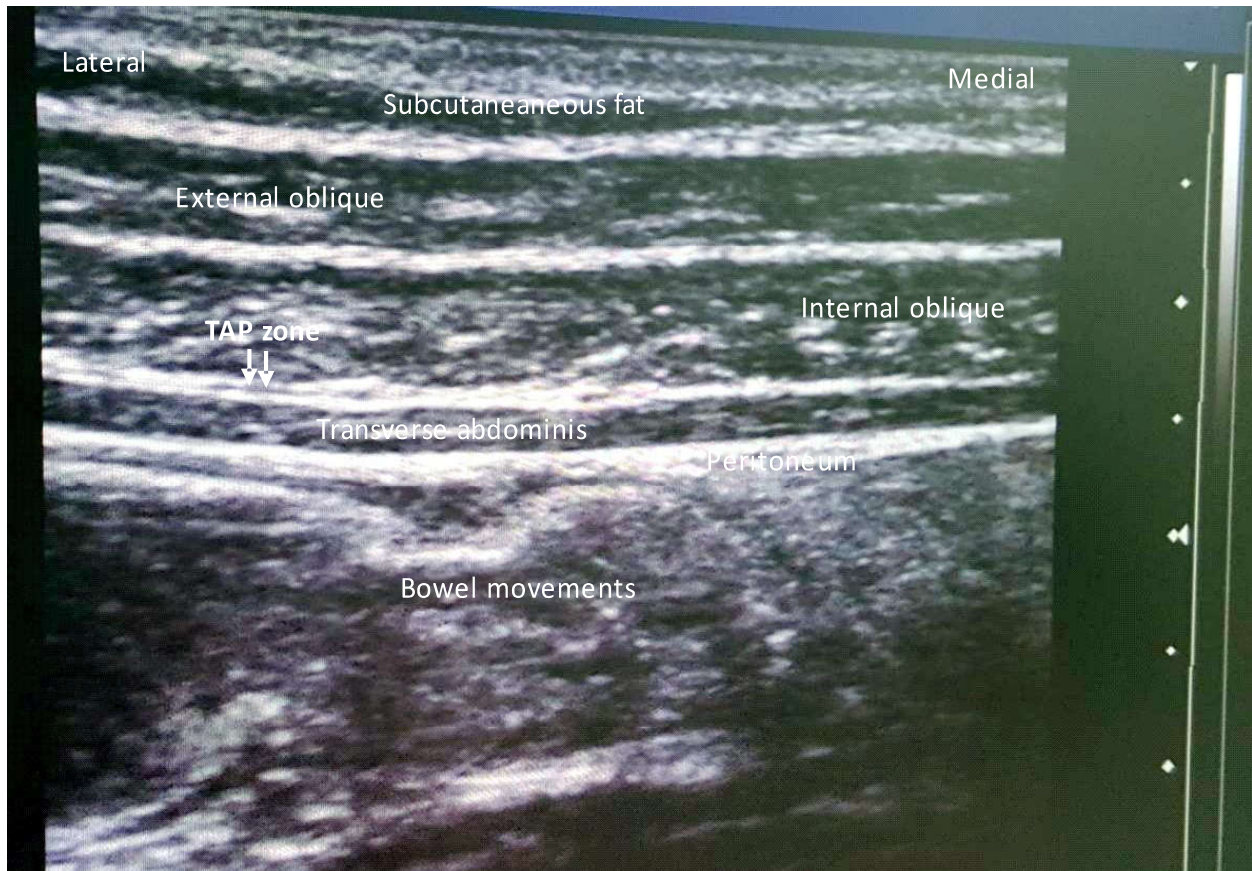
Ultrasonography picture of TAP area showing different layers of anterior abdominal wall muscles
